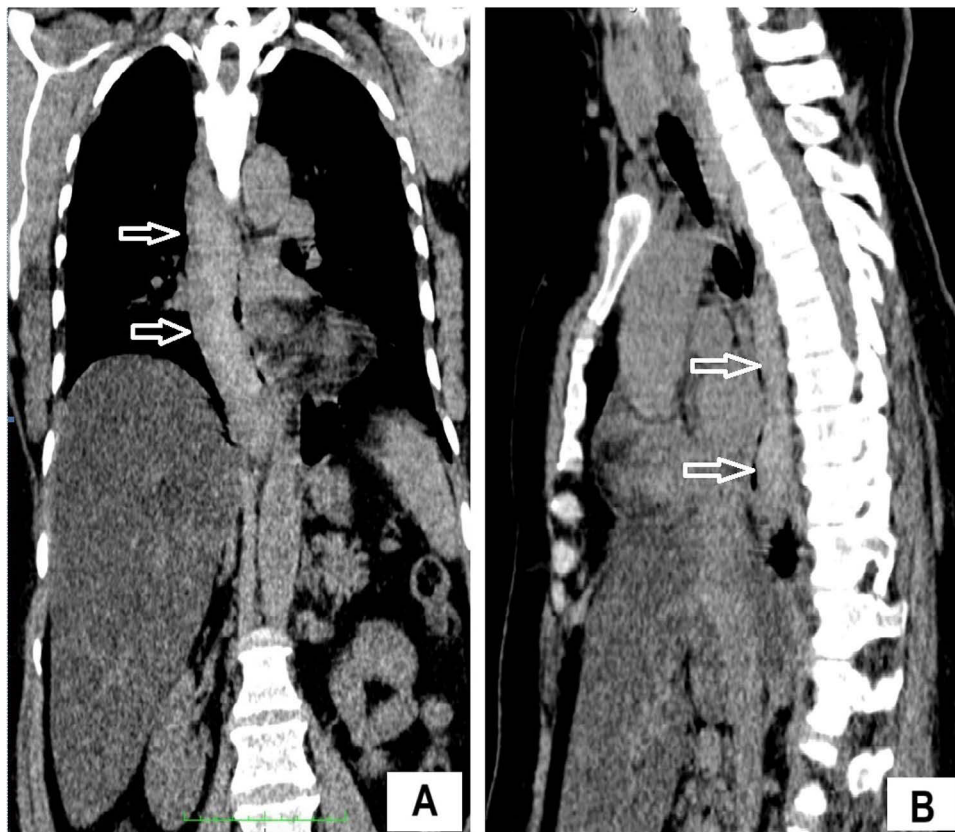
Computed tomography coronal section (A) and sagittal section (B) image showing longitudinal intramural homogenous hyperdensity (white arrows) suggestive of hematoma seen extending from proximal esophagus to gastroesophageal junction.
